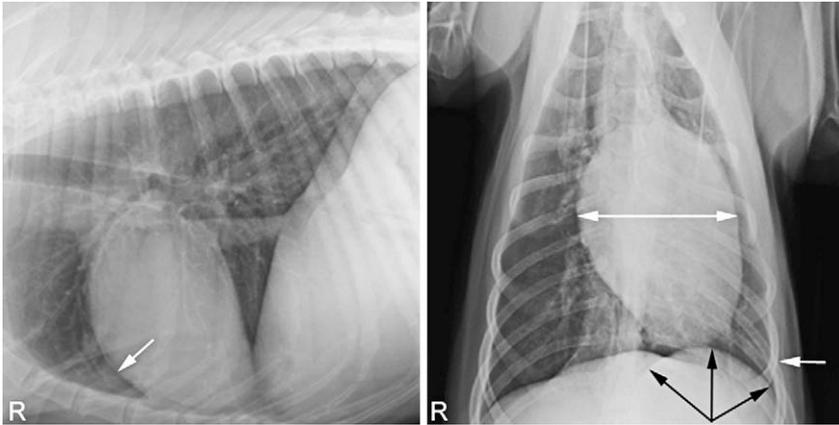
Orthogonal thoracic radiographs of a 9-year-old, neutered, male Weimaraner with atelectasis. On the lateral view, note the increased opacity that obscures the margins on pulmonary blood vessels (*white arrow*). On the ventrodorsal view, note the mediastinal shift of the heart to the left (*double-headed white arrow*), rib crowding (*white arrow*), and cranial displacement of the left crus of the diaphragm (*black arrows*).
